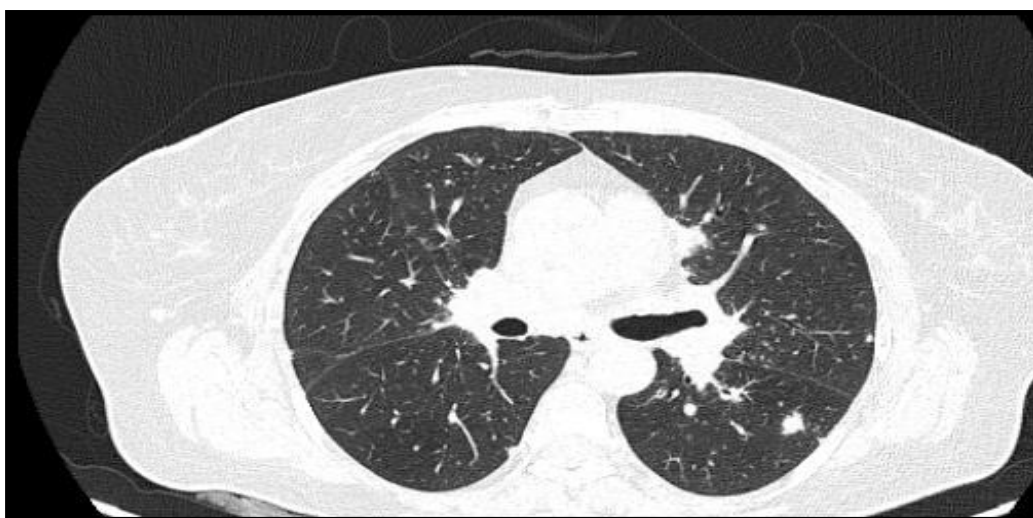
Nodular interface sign seen on HRCT chest with subpleural nodules in a 58 years old female
